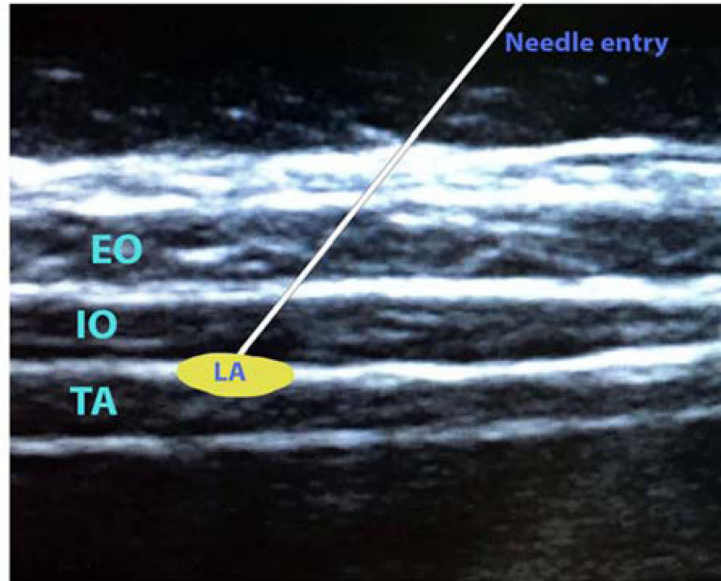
Ultrasound image of transverse abdominis plane block. EO: external oblique muscle, IO: internal oblique muscle, TA: transverse abdominis muscle, LA: local anesthetic
